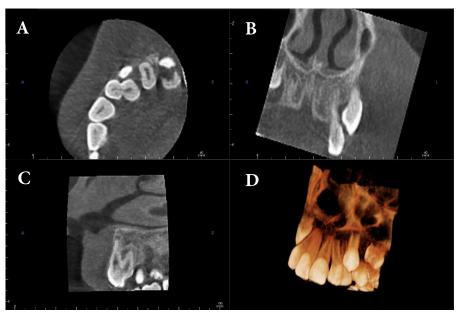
A preoperative cone-beam computed tomographic images showing the double tooth #22-#22bis: *A*) An axial section of the fused teeth, showing the point of communication between the pulp systems; *B*) Coronal section of the teeth; *C*) Sagittal section of the teeth; *D*) 3-D hard tissue reconstruction
